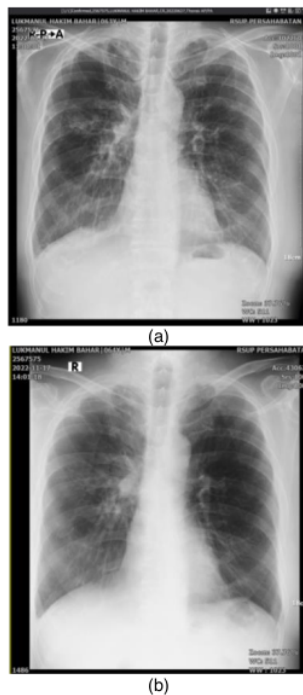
Chest x-ray. (a) June 27th, 2022, (b) November 17th, 2022
